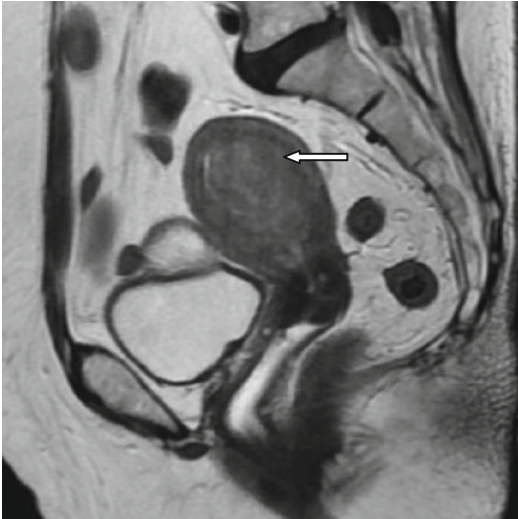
83-year-old lady with history of postmenopausal bleed; T2 sagittal MRI showing mass filling the endometrial cavity (*straight arrow*). Poor tumor to myometrial differentiation is noted, making accurate assessment of myometrial infiltration difficult
